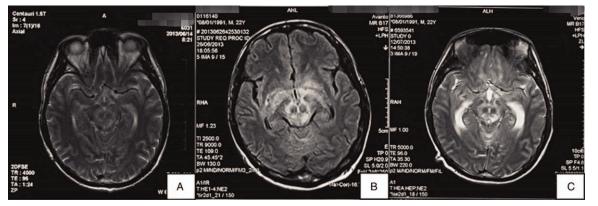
MRI examination: (A) Multipatchy long T1, long T2 signals in the basal ganglia and brain stem; (B) multiple abnormal signals in the midbrain and bilateral cerebral ganglion; (C) multiple abnormal signals with enhancement of 28th day. MRI = magnetic resonance imaging.
